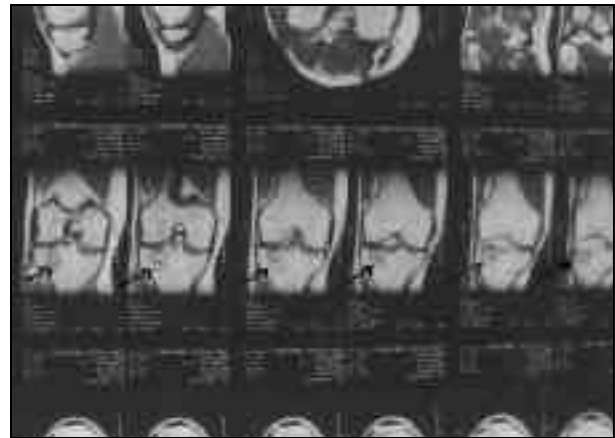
MRI reveals a well circumscribed lesion with a central hypointense nidus
